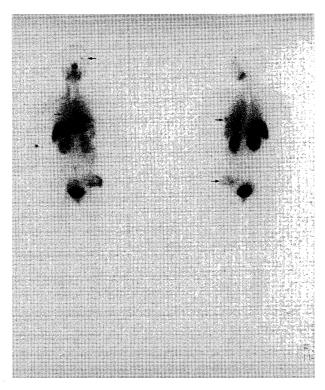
99mTc-MIBI scintigraphy (left: anterior view, right: posterior view) after 131I-Na treatment in Case No. 1. Increased accumulations of bone metastatic lesions in the thoracic vertebrae, and left ilium as well as the thyroid gland disappeared, and those in the left rib, left orbit and sternum decreased.
